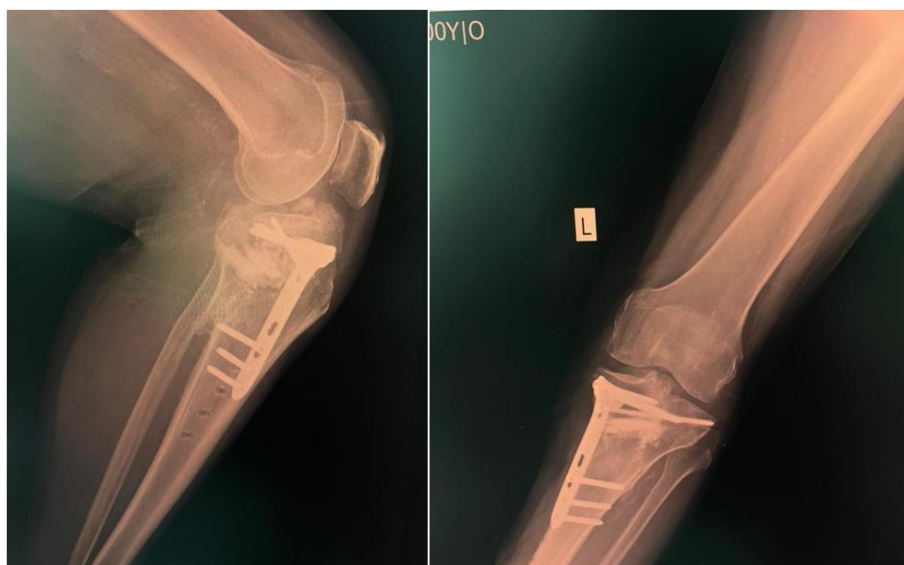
Radiograph of AP and lateral view of post-OWHTO surgical intervention
